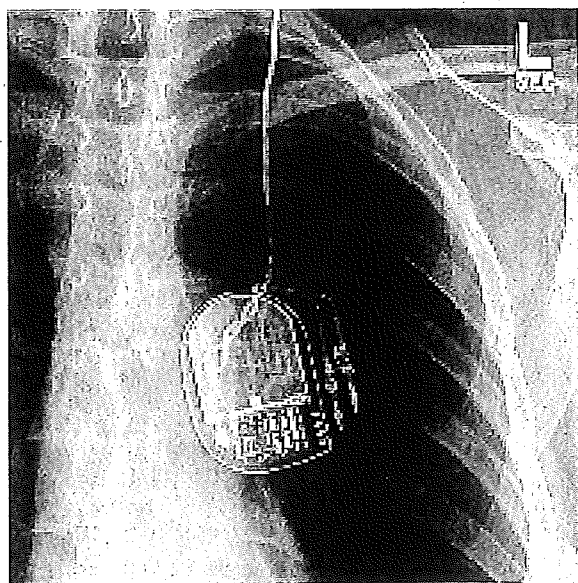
A chest x-ray revealed a twisted extension cable and flipped IPG following a mammography. These features have been referred to as the twiddler syndrome.
